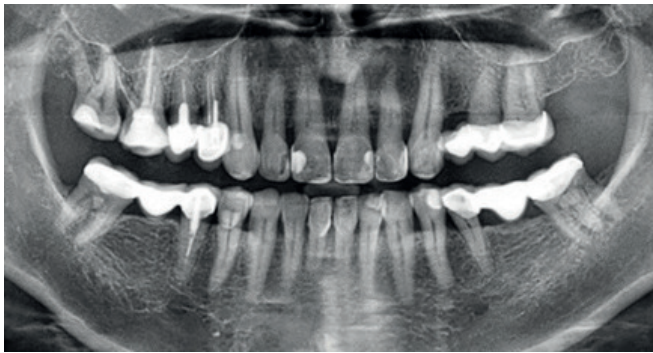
Initial panoramic radiograph. Visualization of atypical anatomy of the root system of 37 tooth. 2D panoramic image shows three roots
